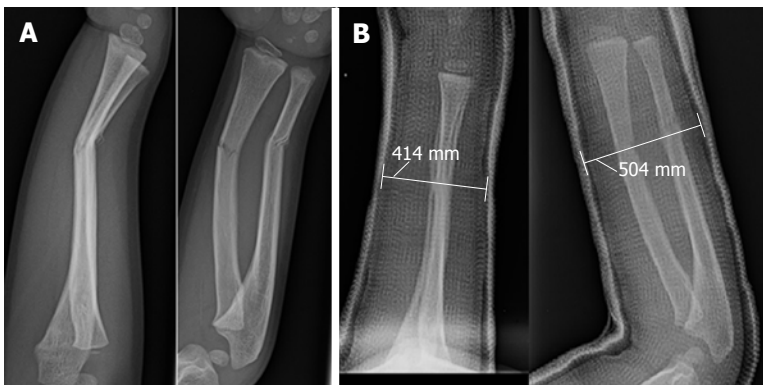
Cast index. A: Initial X-rays of a pediatric forearm fracture with angulation; B: Immediate post-reduction X-rays demonstrating an appropriate cast application based on the cast index (< 0.8). Cast index = Sagittal width/coronal width = 41.4 mm/54.4 mm = 0.76.
